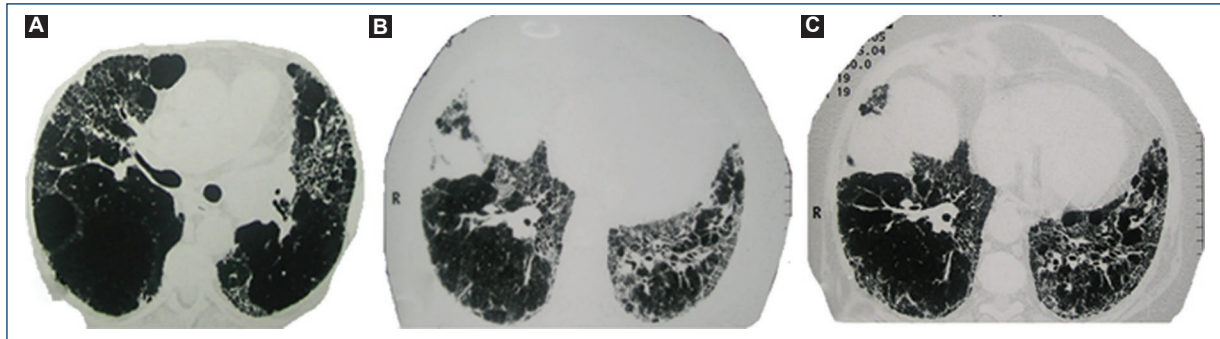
A: CT scan of the thorax where the considerable caliber of the right branch of the pulmonary artery in relation to the aorta can be observed. B: CT scan of fine sections of the chest that in lower regions shows areas of parenchymal distortion, areas of normal structure, and patched areas of ground glass. There are traction bronchiectasis and areas of peripheral panalization, insinuating, however, a peribronchial predominance of opacities. C: chest CT performed 9 months after immunosuppressive treatment, in which an apparent improvement of the ground glass pattern is observed, but an aspect that should be interpreted with caution since the techniques used for CT are clearly different.
